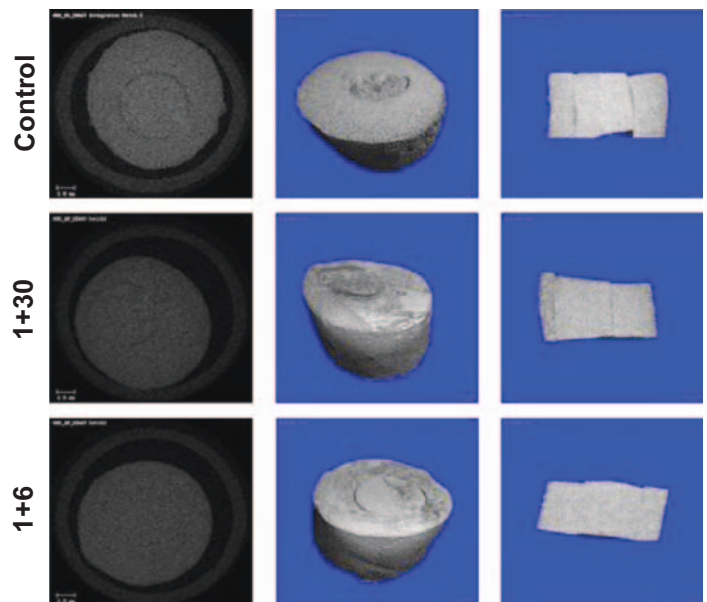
μ CT scans of cartilage-to-cartilage repair constructs. Left: single μ CT scan slice representative of the sample. Center: 3D reconstruction. Right: cross-section of the reconstruction. The μ CT scans demonstrate increasing integration from control to 1+30 to 1+6 treatments.
